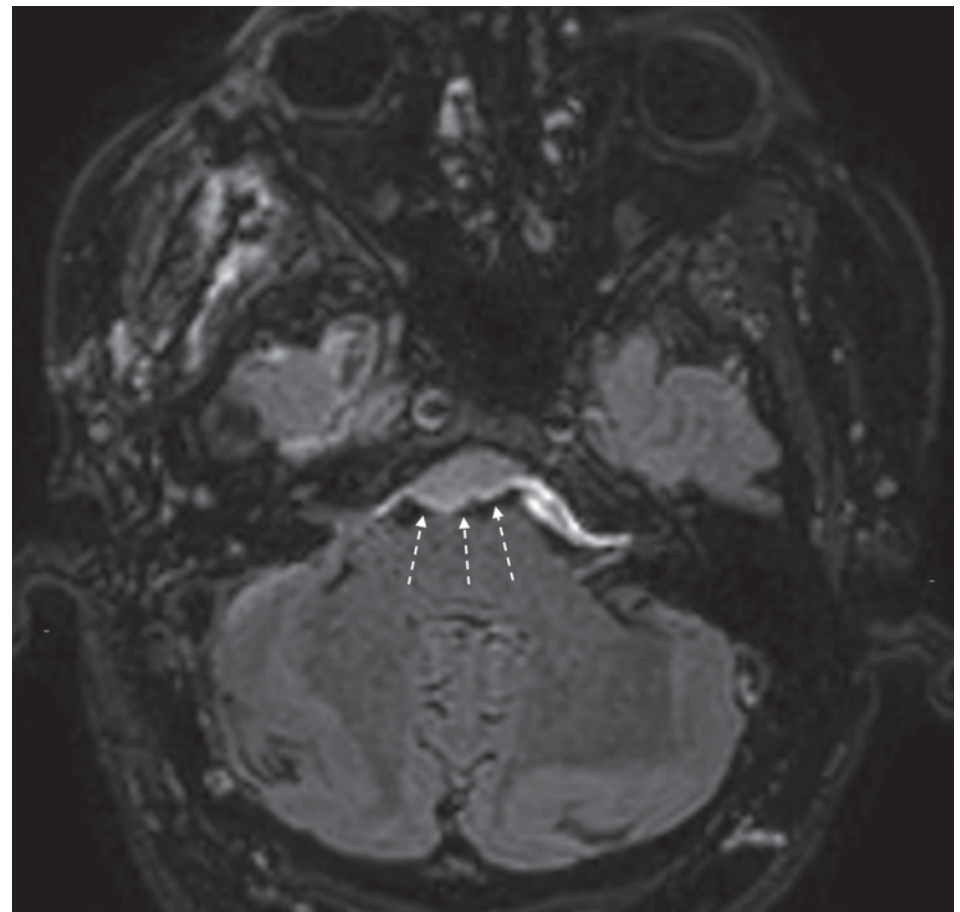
Follow-up axial fat-suppressed FLAIR reveals progression of disease, with tumor extending caudally into the prepontine cistern (thin dashed arrows).
